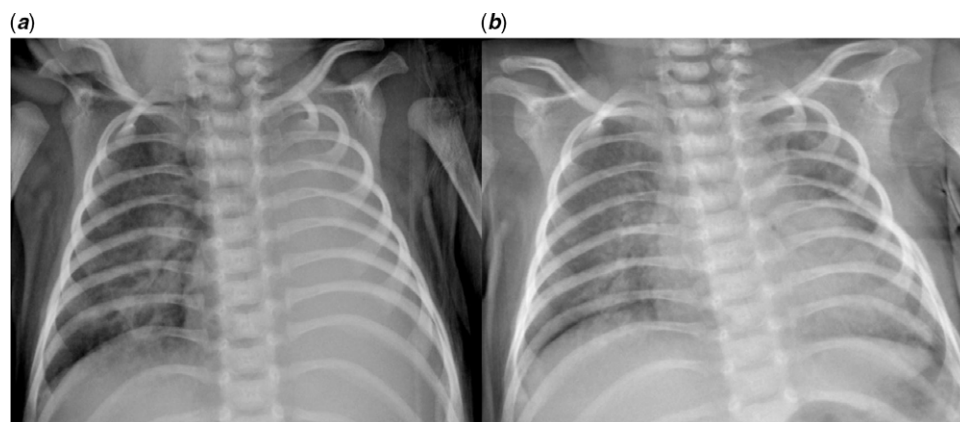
Chest X-ray posteroanterior view. (a) Pre-operative: Completely collapsed left lung; (b) Post-operative: Reexpanded left lung.
